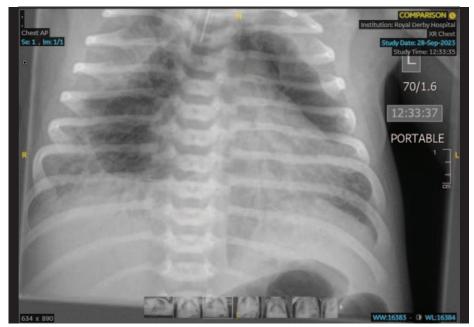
Chest X-ray shows a halo around the heart border which excludes the diaphragmatic border of the heart in the anteroposterior view and a retrosternal translucency in the lateral view.
